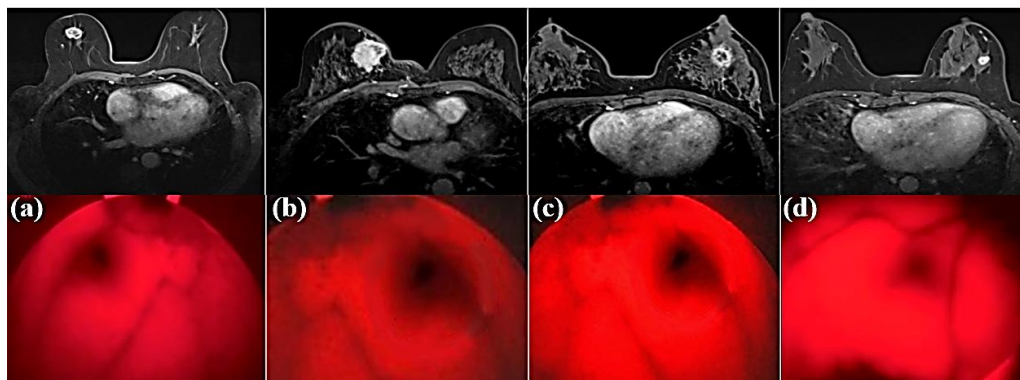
Comparative MRI and infrared thermographic (IRT) scans of selected patients: (a) Hoang Thi T; (b) Vu Thi K; (c) Pham Thi Y; (d) Le Thi H.
